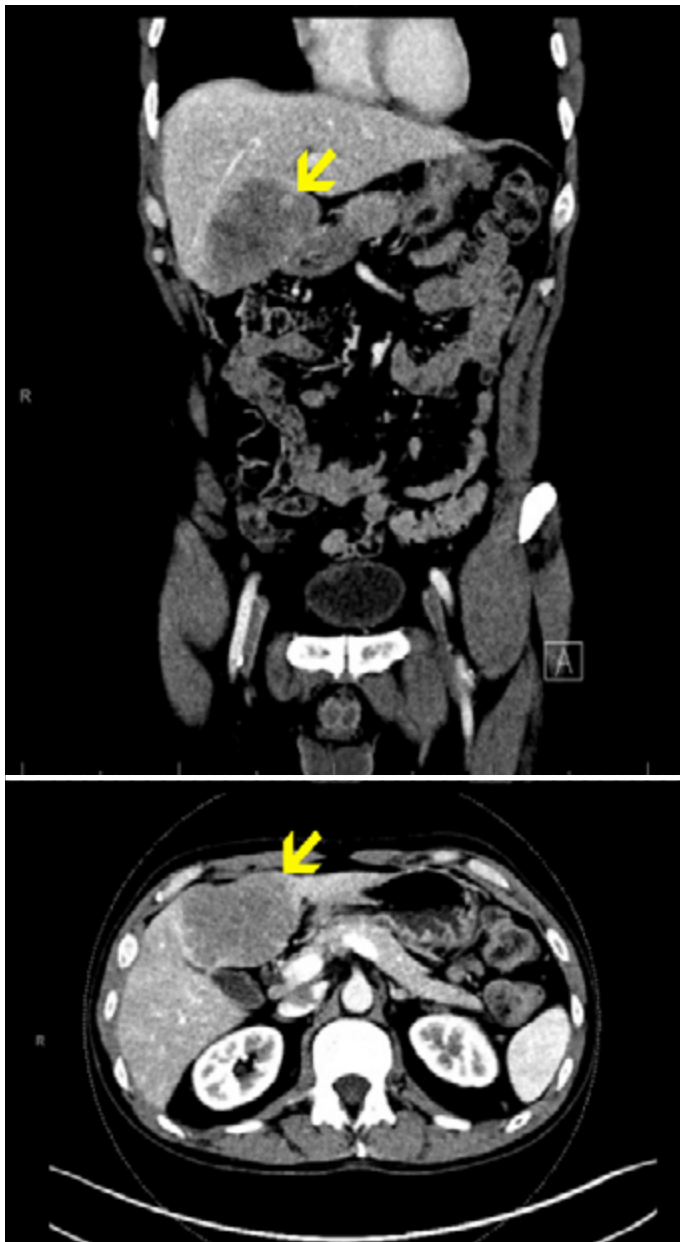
Computed tomography images of the abdomen and pelvis identifying a segment IV hypoattenuating liver mass measuring 6.2 x 4.1 x 5.8 cm with ill-defined margins and overlying capsular retraction.
